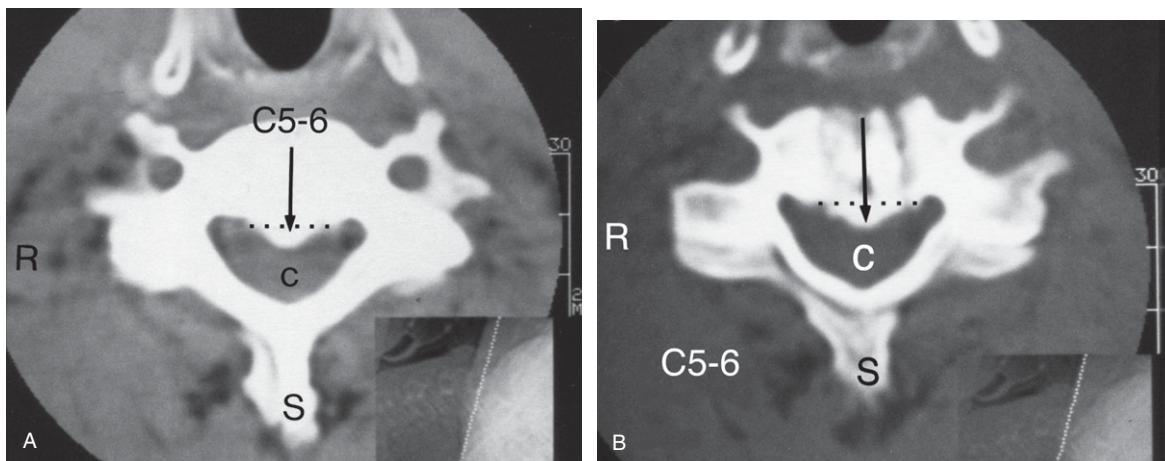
(A and B) Cervical spine CT axial image (performed 3 years following the Cloward procedure) through the C5–6 level using a *soft tissue exposure* (A) and a *bone window exposure* (B). Note the bony 'plug' (black arrow) extending beyond the normal posterior margin of the vertebral body (broken line) into the spinal canal and impinging upon the spinal cord (c) (A). The antero-posterior diameter of the spinal canal is 9.5 mm from the lamina junction posteriorly to the bony 'plug' anteriorly and, therefore, is stenotic as a result of the bony 'plug' that causes pressure upon the anterior surface of the spinal cord. S = spinous process.
